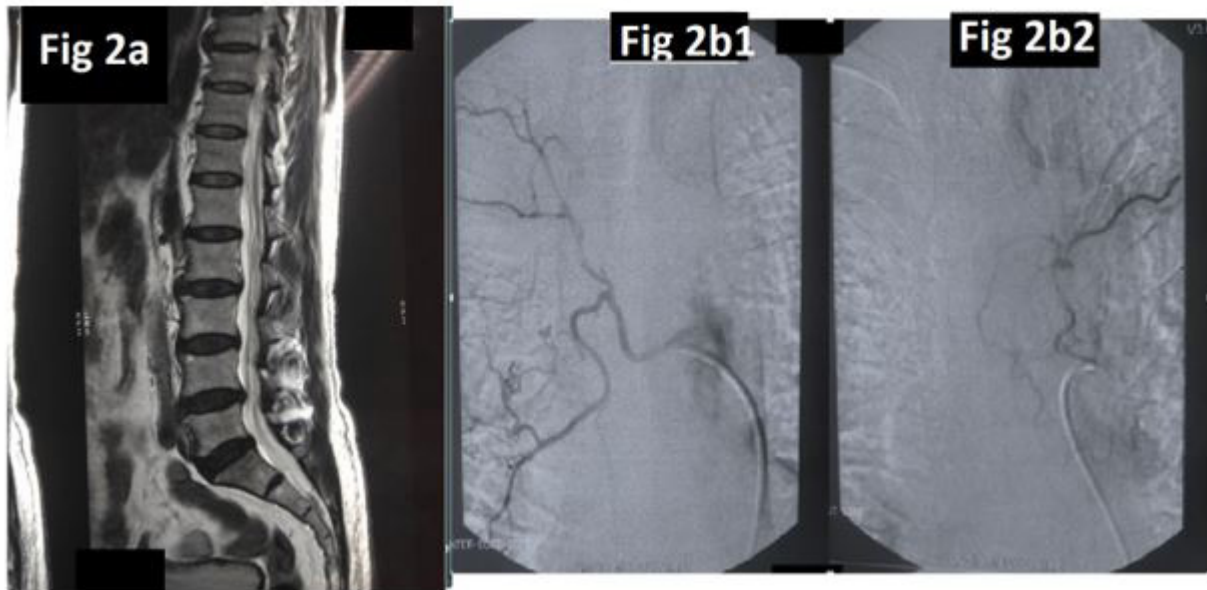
(a) The spinal cord MRI showed a serpiginous appearance of the lumbar vessels, a lumbar hypersignals and a terminal cone hypersignal. (b) Angiography confirmed the complete exclusion of the old fistula (Figure 2b1) and the presence of a 2nd dural fistula supplied by a radiculo-meningeal branch of the 1st left lumbar artery (Figure 2b2), not seen on the 1st angiogram
